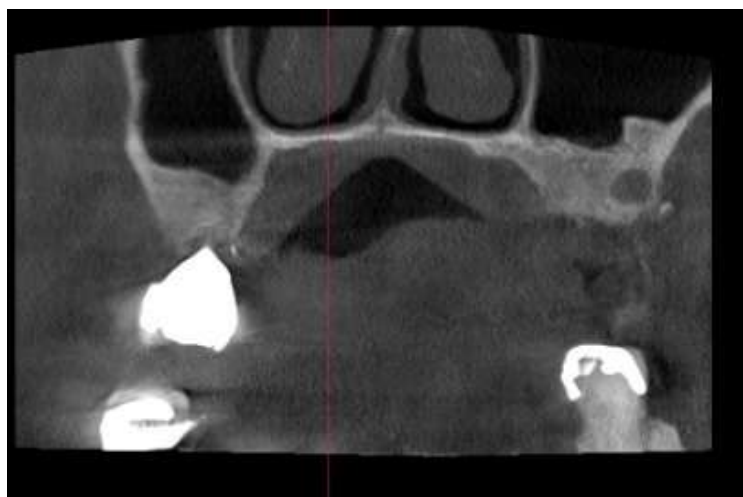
Closeup view of CBCT
